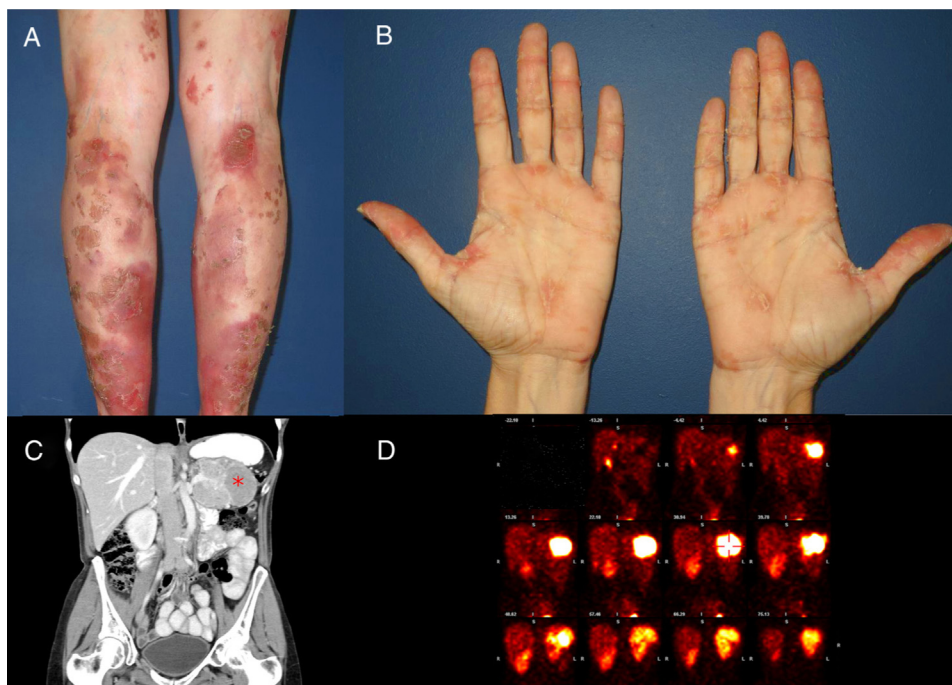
A) Erythematous to violaceous coloured, annular plaques on both legs, with well-defined borders and central epidermal detachment suggestive of migratory necrolytic erythema. B) Epidermal detachment and desquamation on both palms. C) Computed tomography: polylobulated mass in the pancreatic tail of 82 × 53 × 61 mm (*) compatible with primary pancreatic tumour. D) A SPECT scan using radiopharmaceutical ¹¹¹In-octreotide: neoplastic process in the pancreatic tail with somatostatin receptors suggestive of glucagonoma.
